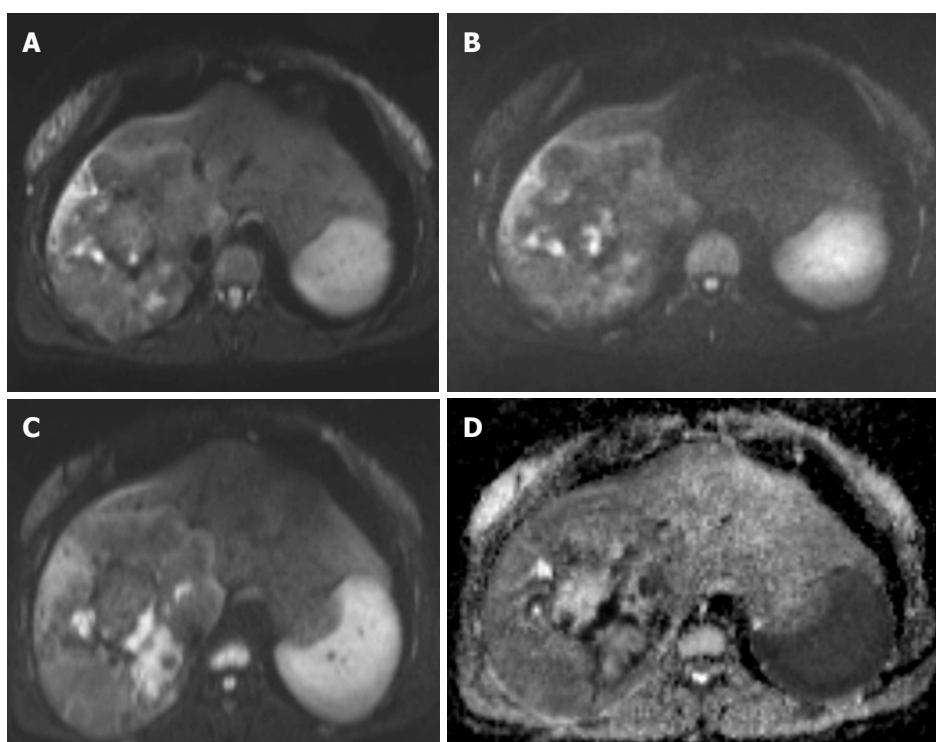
Alveolar echinococcosis in a 44-year-old man. Diffusion-weighted magnetic resonance images obtained with b values of 400 sec/mm^2 (A), 800 sec/mm^2 (B), and 1000 sec/mm^2 (C) and corresponding apparent diffusion coefficient map (D) show signal hyperintensity in a hepatic mass.
